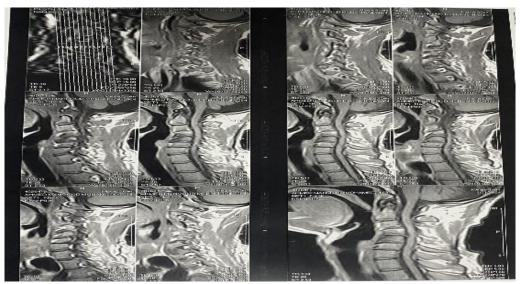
Sagittal cervical radiographs. T1 (C3/C4) Down to (C6/C7) Posterior Disc Degenerative Lesion with Reversed Cervical Lordosis Curve, No abnormality detected in the paraspinal Soft Tissue.
